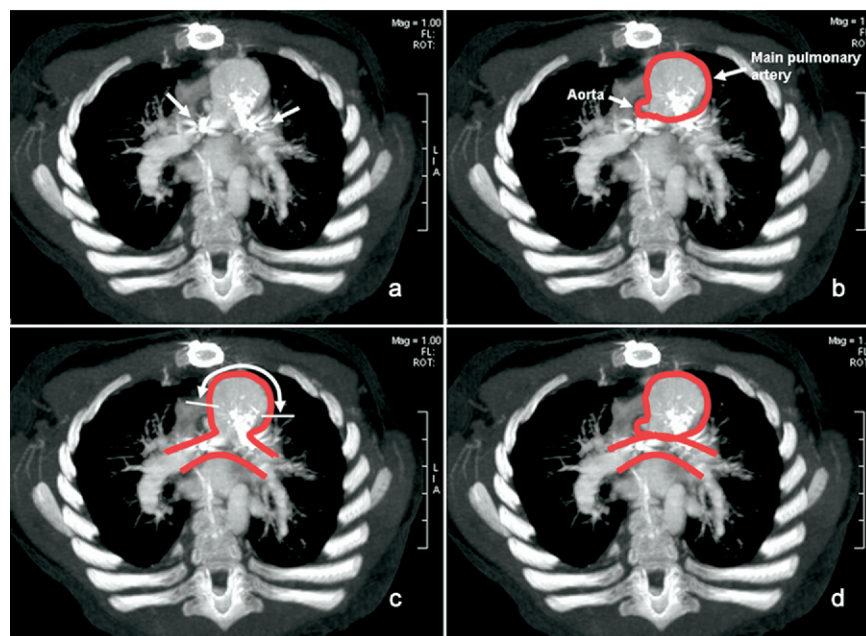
Representative computed tomography scan of a patient after the hybrid procedure immediately before stage II palliation. The bilateral pulmonary artery bands are seen in (a). The aorta and main pulmonary artery are outlined in (b). Panel c outlines the pulmonary artery confluence, which must remain posterior to the reconstructed aortic arch (composed of the ascending aorta and homograft of approximately the same diameter as the main pulmonary artery). The central confluence typically is bulky and excessive and can cause pulmonary artery compression through twisting and kinking when left intact behind the reconstructed aortic arch. Generous resection at the points marked by the curved arrow results in a slender, nonobstructive pulmonary artery confluence (d).
